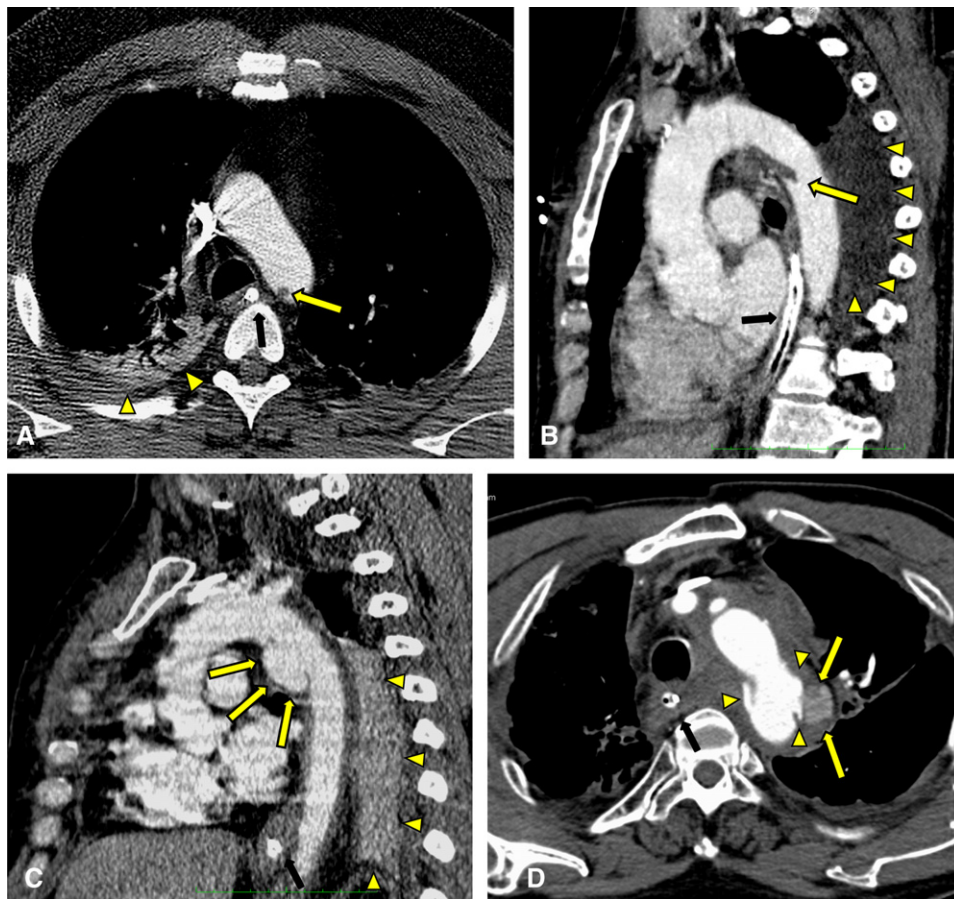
A, Vancouver simplified grade I blunt aortic injury (thrombus, intimal flap, or intramural hematoma <1 cm). A small thrombus (<1 cm) is seen in the aortic lumen just distal to the left subclavian artery branch (yellow arrows) in this axial slice of a postcontrast CT scan. A zone of lung consolidation is seen in the right lung (yellow arrowheads), and a nasogastric tube is present in the esophagus (solid arrow in A). B, Vancouver simplified grade II blunt aortic injury (thrombus, intimal flap or intramural hematoma >1 cm). A large thrombus (>1 cm) is seen in the aortic lumen at the site of the aortic isthmus (yellow arrow) in this oblique sagittal reformat of a postcontrast CT scan. Pleural effusion and hemothorax is seen (arrowheads), and a nasogastric tube is present in the esophagus (solid arrow). C, Vancouver simplified grade III blunt aortic injury (pseudoaneurysm, simple or complex, without extravasation). A large pseudoaneurysm is seen bulging from the aortic lumen at the site of the aortic isthmus (yellow arrows) in this oblique sagittal reformat of a postcontrast CT scan. A zone of lung consolidation is seen in the left lung (arrowheads), and a nasogastric tube is present in the esophagus (solid arrows). D, Vancouver grade 4 blunt aortic injury (active contrast extravasation). A large irregular pseudoaneurysm is seen bulging from the aortic lumen at the site of the aortic isthmus (yellow arrowheads) in this axial slice of a postcontrast CT scan. Active contrast extravasation from the irregular pseudoaneurysm is seen to extend into the mediastinum (yellow arrows), which is obliterated by hematoma. A nasogastric tube is present in the esophagus (solid arrow), and the trachea and esophagus are clearly displaced.
